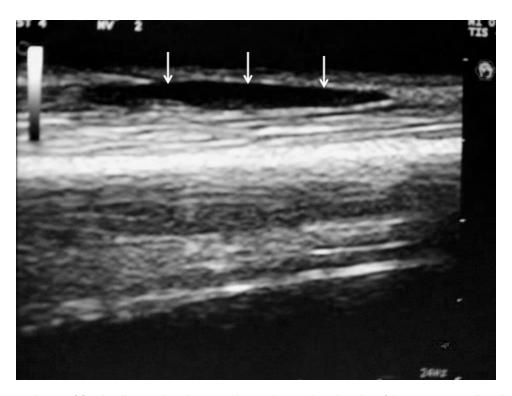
Evidence of fluid collection by ultrasound over the tendon sheaths of the extensor pollicis brevis (EPB) and abductor pollicis longus (APL) at the level of their intersection with the extensor carpi radialis brevis (ECRB) and extensor carpi radialis longus (ECRL).
